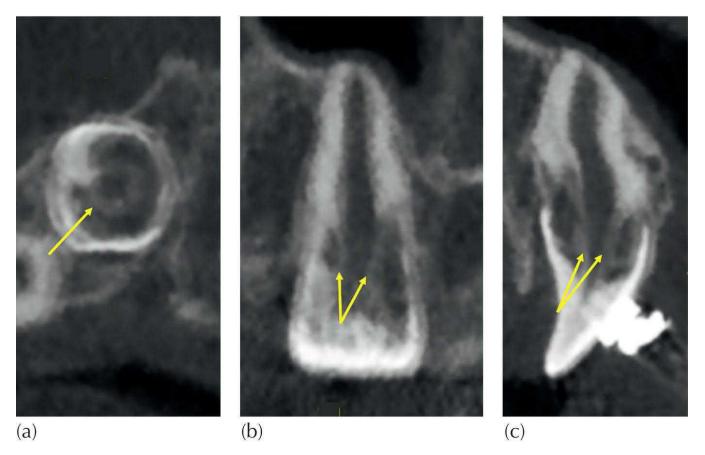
An advanced invasive cervical root resorption lesion in an impacted incisor. The images were extracted from the multiplanar reformatting reconstruction of the cone beam computed tomography. (a) An axial slice in the cemento-enamel junction (CEJ) area. (b) A coronal slice and (c) a cross-sectional slice. The innermost dark (radiolucent) area indicates the root canal, encompassed by the slightly radiopaque pericanalar circle, indicated by the yellow arrows. The third concentric circle is the wider area of almost total root resorption, which is encircled by the delicate enamel outer layer at the CEJ. The enamel is thinned by resorption too, and unsupported other than by the soft, radiolucent, resorption mush.
